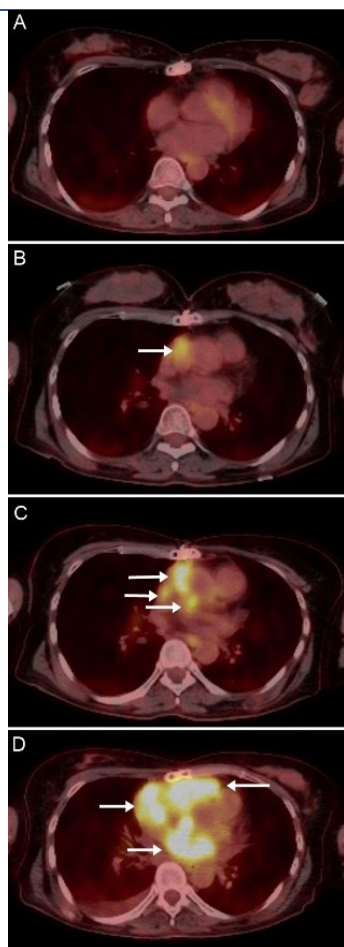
Axial fused [^{18}F]FDG PET/CT images obtained on postoperative day 40 (A), and at 4 months (B), 9 months (C), and 23 months (D)
